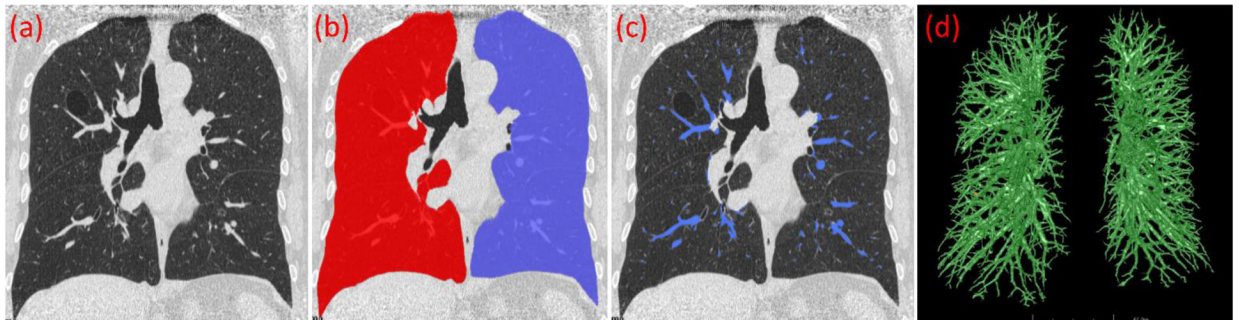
Intrapulmonary vessels identified using the developed differential geometry method and multiple thresholds $[-700 \text{ HU}, -200 \text{ HU}]$. (a) original CT image, (b) segmented lung, (c) intrapulmonary vessels detected, and (d) 3-D visualization of the detected vessels.
